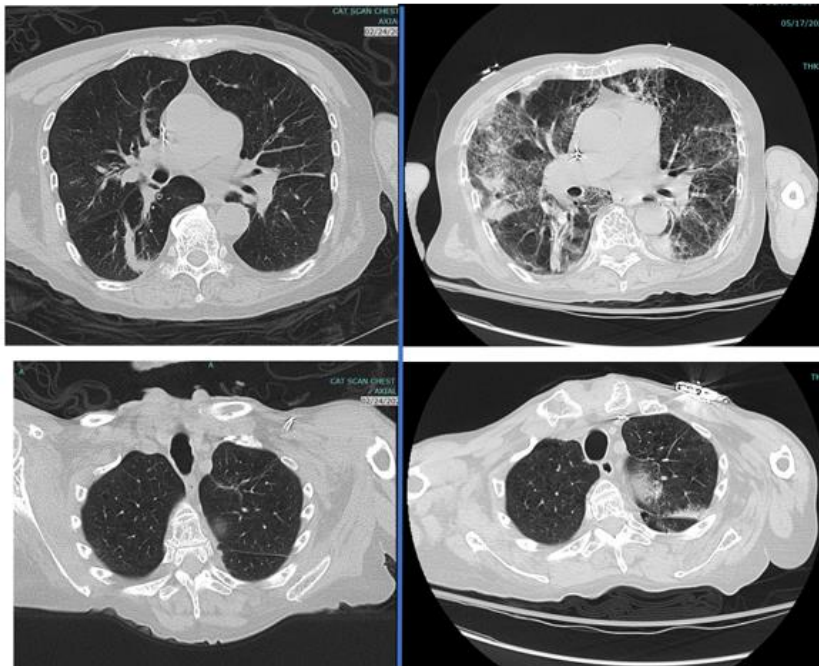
Side-by-side comparison of chest CT from 2/24/20 (left) and 5/17/20 (right). Mid-chest images on top. More apical views on bottom.
